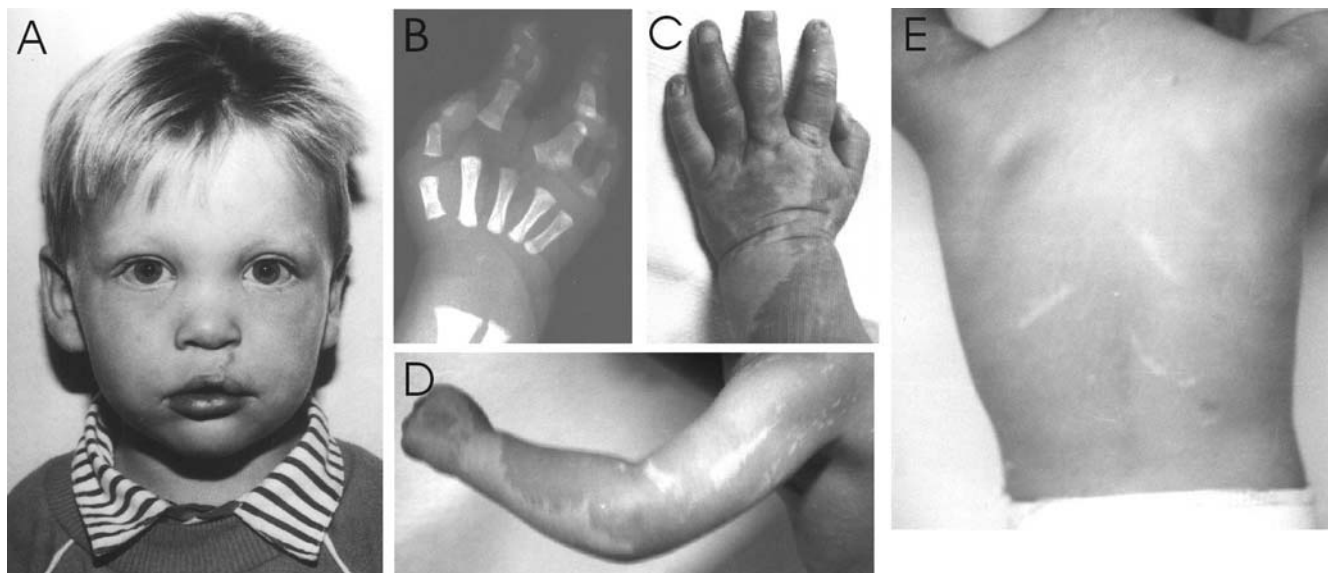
A Note unilateral cleft lip after surgery as well as sparse eye brows and lashes at the age of 2 years. B Radiograph of the right hand of the newborn showing ectrodactyly, duplication of the middle phalanges of the index finger and broad, distally tapering proximal phalanx of the third finger. C Former syndactyly between fingers III and IV on the left. D, E Note generalised and linear distribution of hypopigmentation
